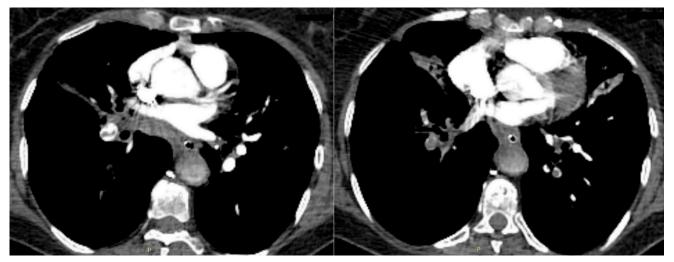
Thoracic CT Angiography (pulmonary embolism causing filling defect in pulmonary artery branches bilaterally)
